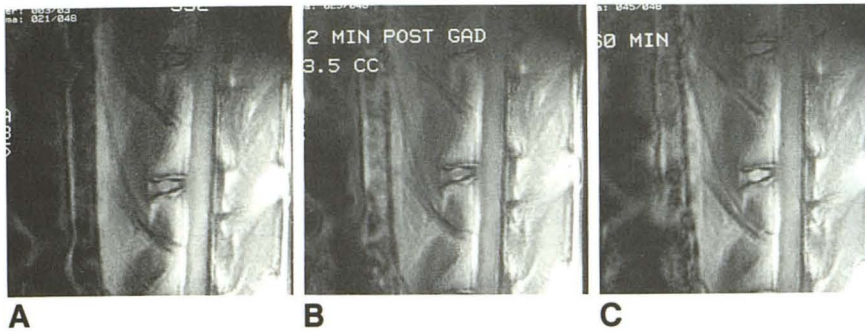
T1-weighted MR images before (A) and at 2 (B) and 60 (C) minutes after intravenous administration of 0.6 mmol/kg of gadopentetate dimeglumine. Note that at 2 minutes there is a narrow band of increased signal intensity near the vertebral end plates, and at 60 minutes the disk has generally increased signal intensity.
